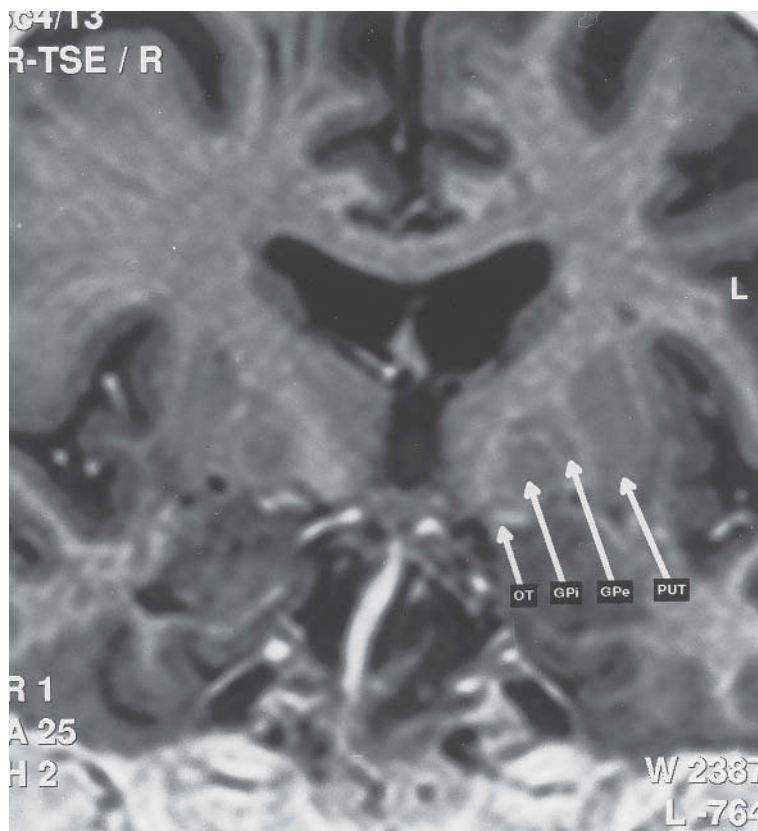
A coronal MRI anterior to the mamillary bodies demonstrates the anatomy of the GPI bounded by the optic tract (OT) ventrally, the internal capsule medially, and the external segment of the globus pallidus (GPe) and putamen (PUT) laterally.
